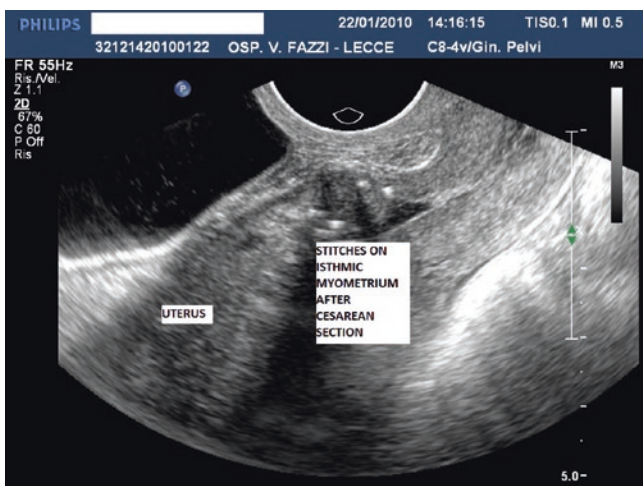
Transvaginal ultrasonographic scan on the uterus on the 30th after a cesarean section; the images show the presence of stitches on isthmic myometrium
